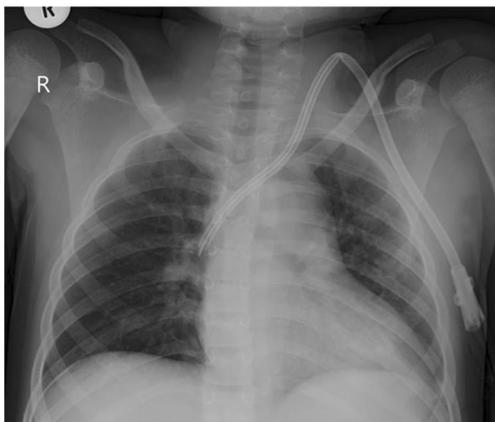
Chest radiograph showing CVAD kinked at the insertion site in the neck, causing occlusion. When inserting the line, care should be taken to ensure an easy curve, which allows for unrestricted flow
